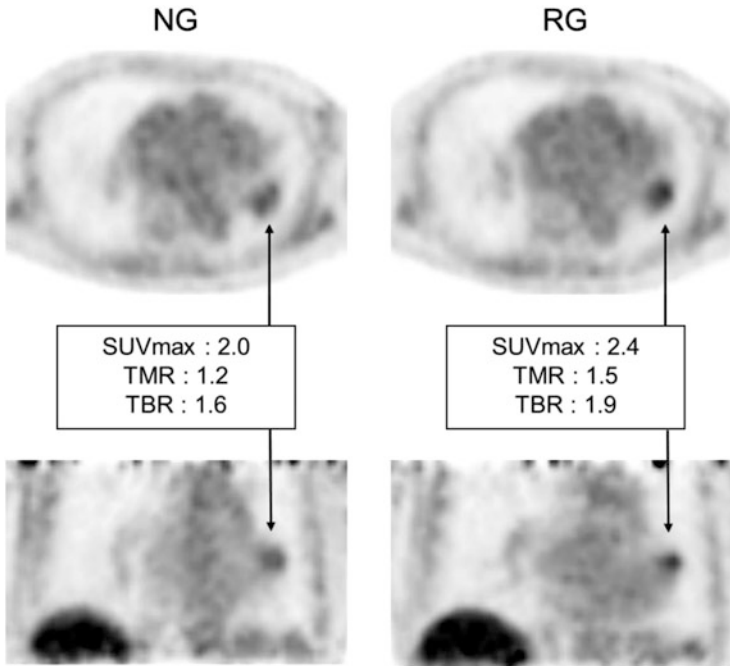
Axial and coronal sections of NG and RG PET images of a patient with a NSCLC lesion in the left lower lobe. In addition to the difference in morphological appearances of the lesion between the NG and RG images, there are considerable increases in SUVmax, TMR, and TBR
